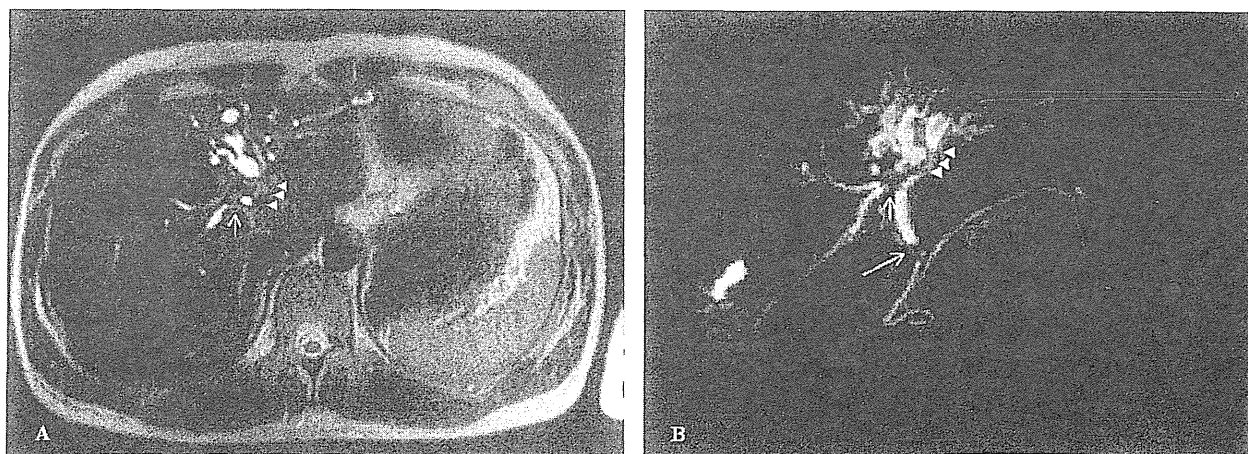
Magnetic resonance imaging (A) and cholangiopancreatography (B) showed stenosis of the left hepatic duct (arrowhead) with dilation of the intrahepatic bile duct in the medial and lateral segments, right hepatic duct (small arrow), and common bile duct (large arrow).
